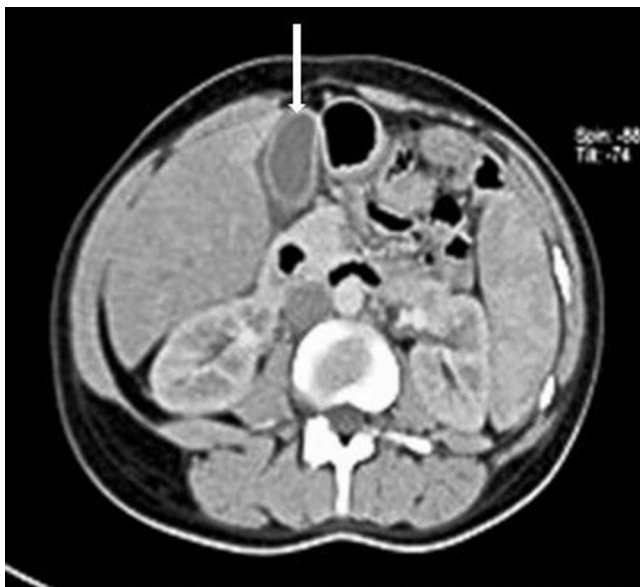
Abdominal CT show gallbladder wall thickness without stone with edema around (arrow).
